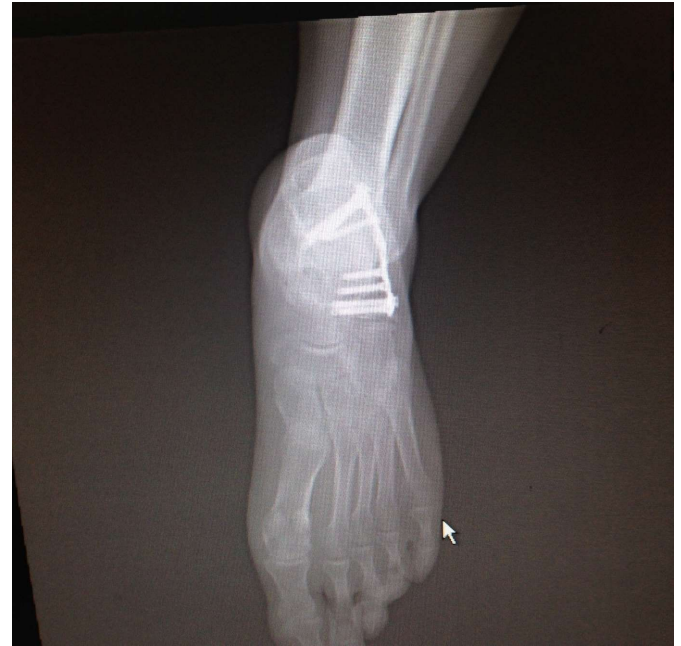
Anteroposterior radiographic view at the postoperative 23rd month.
